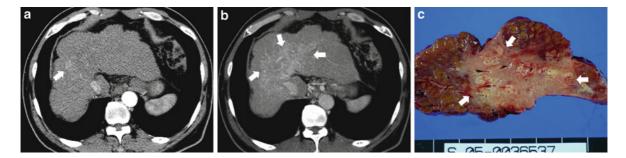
Confluent fibrosis showing arterial and delayed enhancement. a Arterial phase CT scan reveals nodular contour of the liver, and an indistinct, subtle enhancing area (*arrow*) in right anterior segment of the liver. b Portal phase CT scan shows a poorly marginated, delayed enhancing central zone
